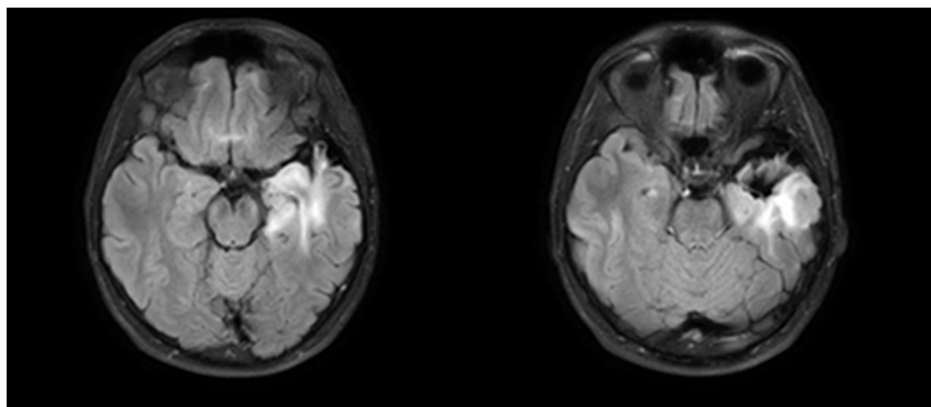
Progression on follow-up T2 FLAIR signal.
